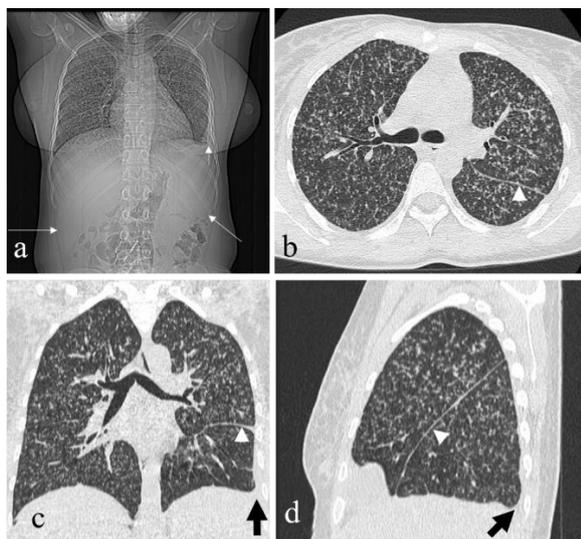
Chest CT (lung window). Scannogram (a) showing disseminated lung micronodules, left costophrenic angle blunting (short arrow) and an enlarged silhouette of the liver and spleen (long arrows). On reformatted axial (b), coronal (c) and sagittal (d) sections there are multiple lung micronodules disseminated in a random pattern. There is thickening of the left lung major fissure (white arrowheads) and blunting of the left lateral and posterior costophrenic angles (thick black arrows).
